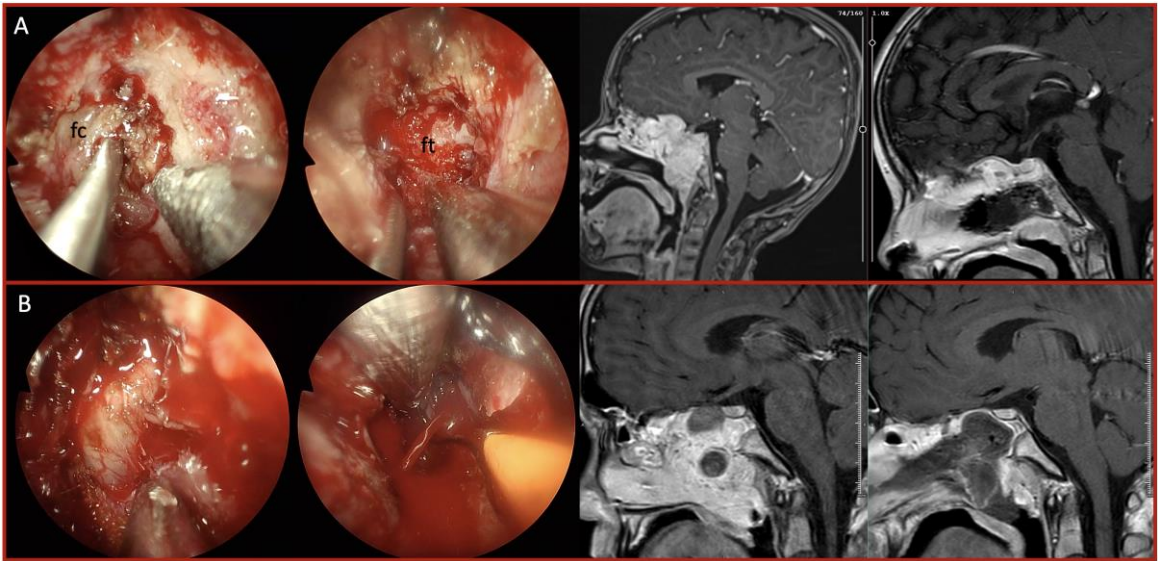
A. EEA in a 4-year-old patient with a predominantly sinus-based lesion. Intraoperatively, a very firm and fibrotic mass was encountered. STR was achieved with the assistance of an ultrasonic aspirator.
